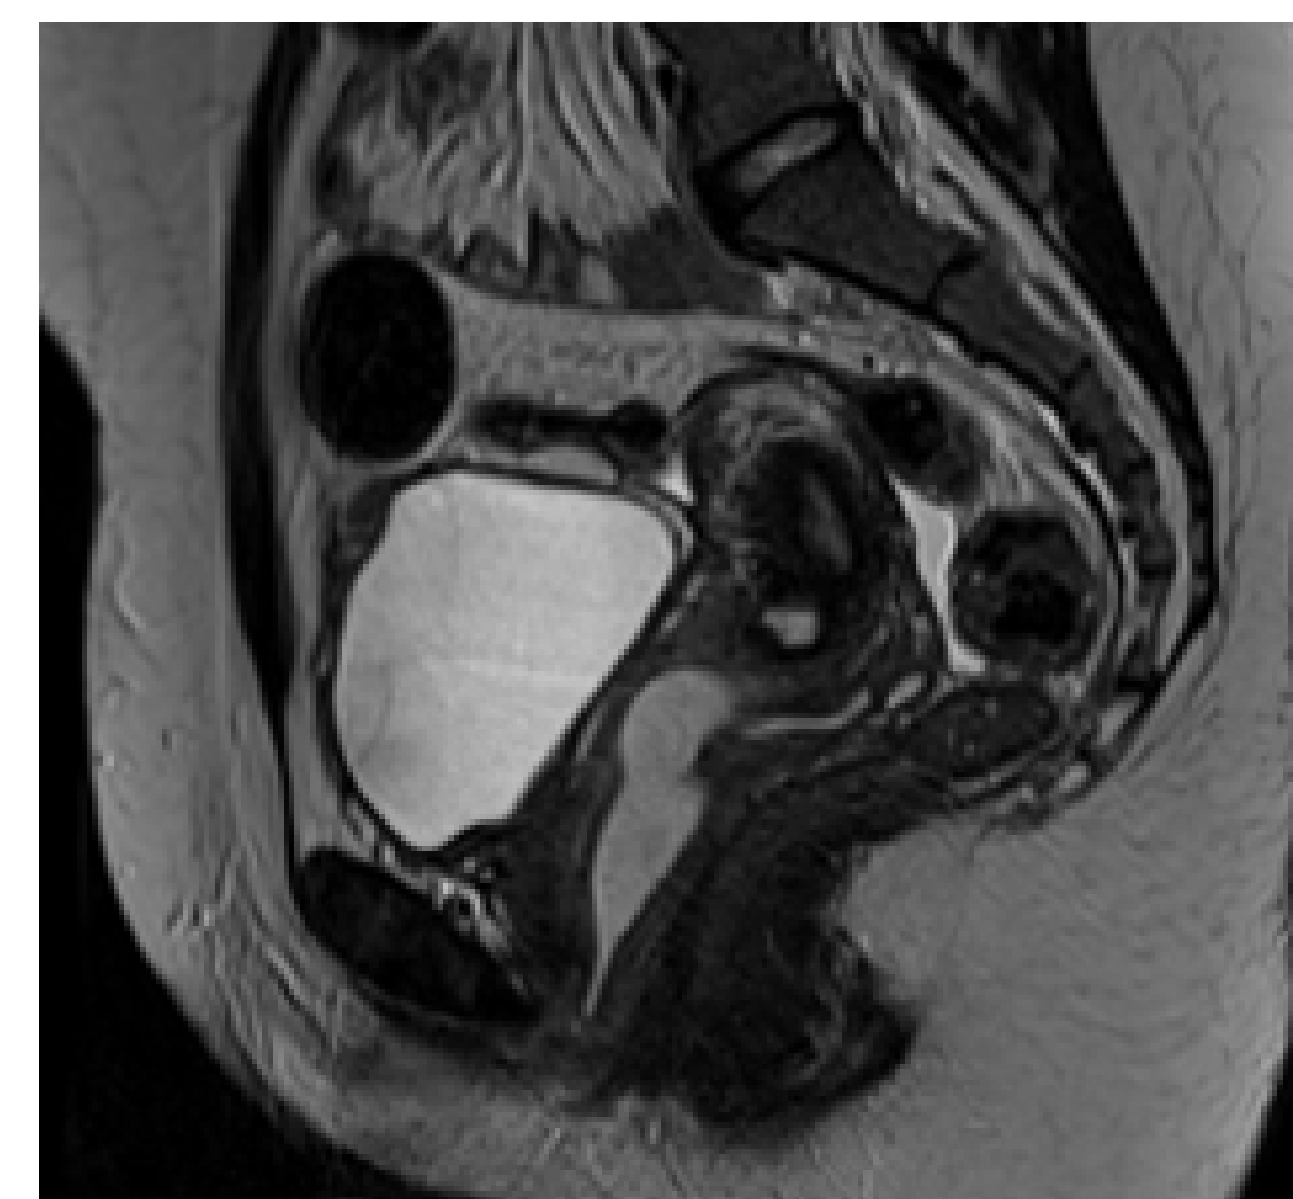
MRI Pelvis. T2 Sagittal section demonstrating pyocolpos and one side of the duplicated uterine cavities.
